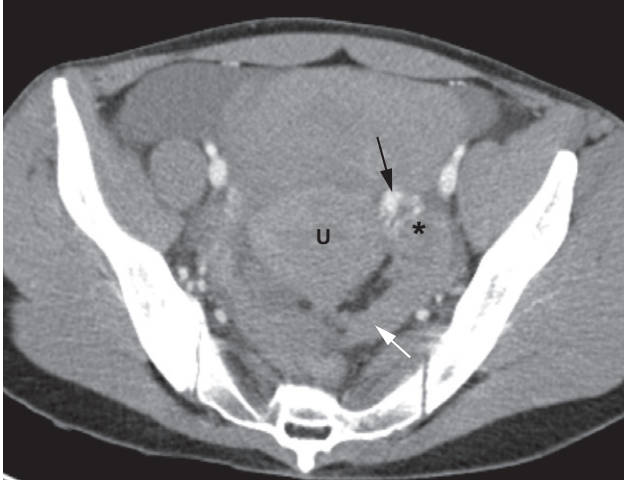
Ruptured ectopic pregnancy on CT. There is a left adnexal mass (*) with leakage of intravenous iodinated contrast (black arrow) due to bleeding. There is high density fluid in the pelvis and pouch of Douglas (white arrow) consistent with haemorrhagic ascites. U, uterus.
